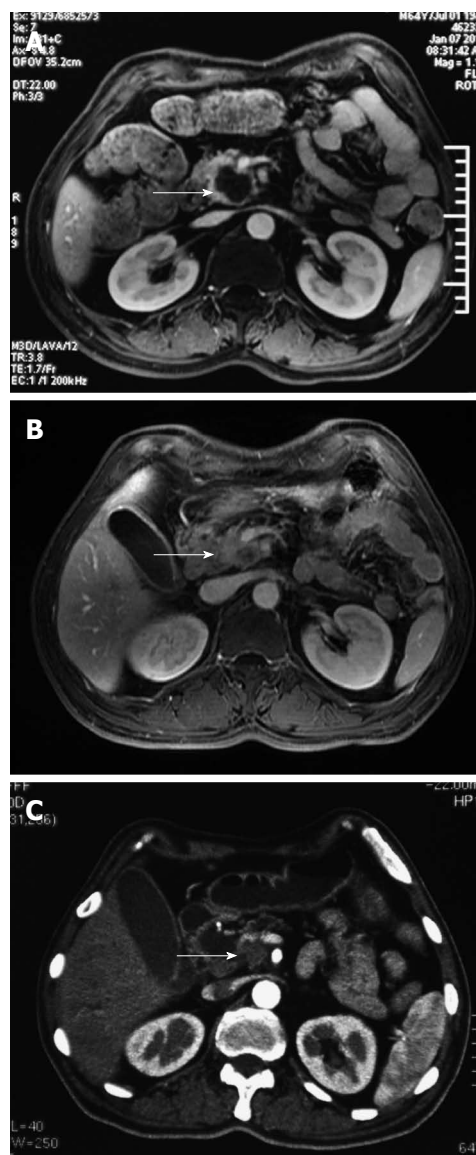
Contrast-enhanced magnetic resonance imaging of the pancreas. A: Before treatment, a mass was observed (arrow) in the head of pancreas; B: Marked shrinkage of the mass was seen after two treatment cycles; C: Mass size remained stable after four treatment cycles.
